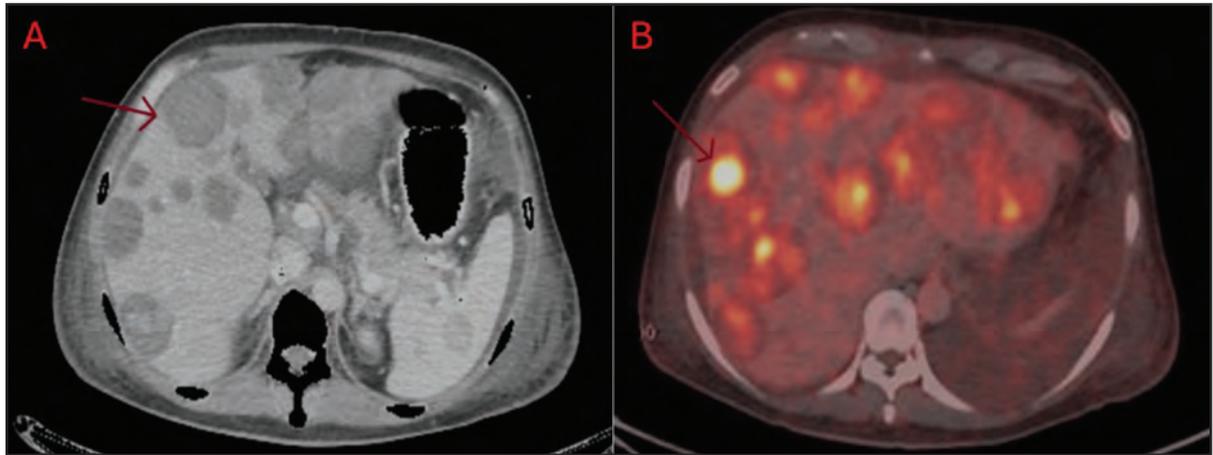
Imaging Finding for Case 1: (A) Transaxial CT image showing multiple hypodense lesions in the liver (red arrow); (B) Corresponding PET/CT fusion image demonstrating diffusely increased FDG uptake in the liver (red arrow)
